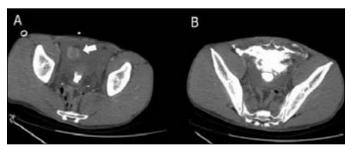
An active hemorrhage was revealed on enhanced computed tomography due to contrast extravasation (arrow) (A). The cystogram revealed extraperitoneal bladder rupture (B).
